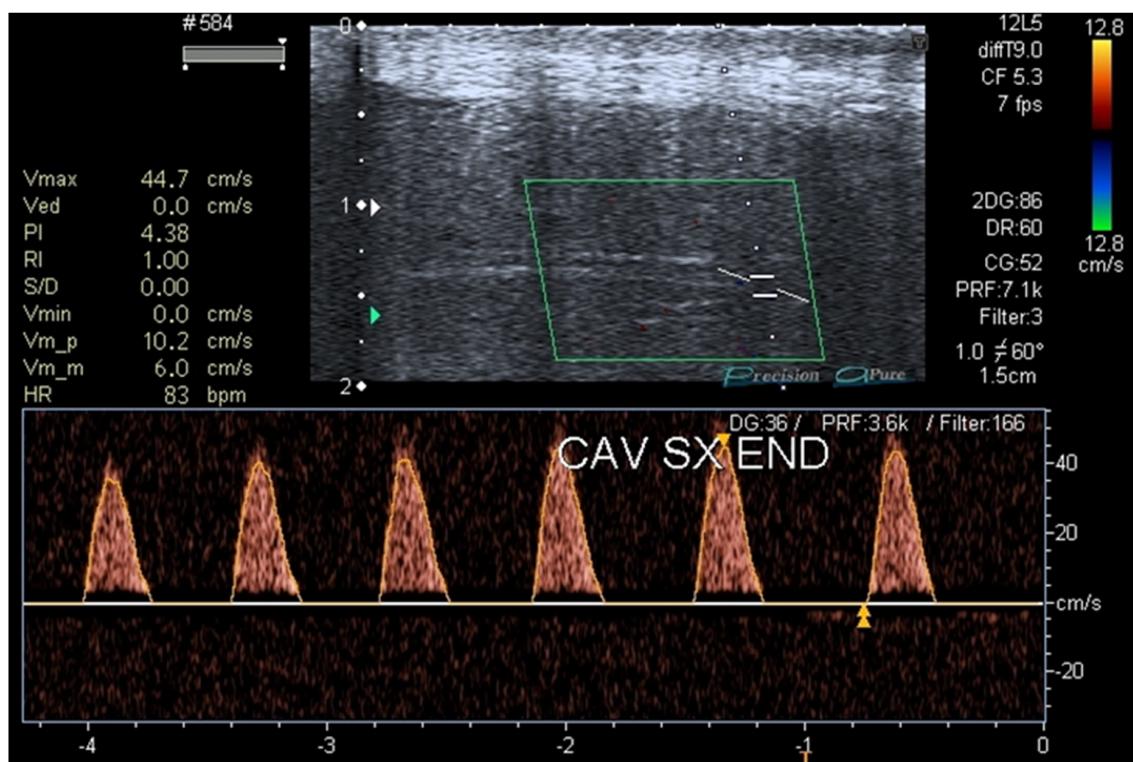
Penile duplex ultrasound at T3 (18 months after patient's first visit).
